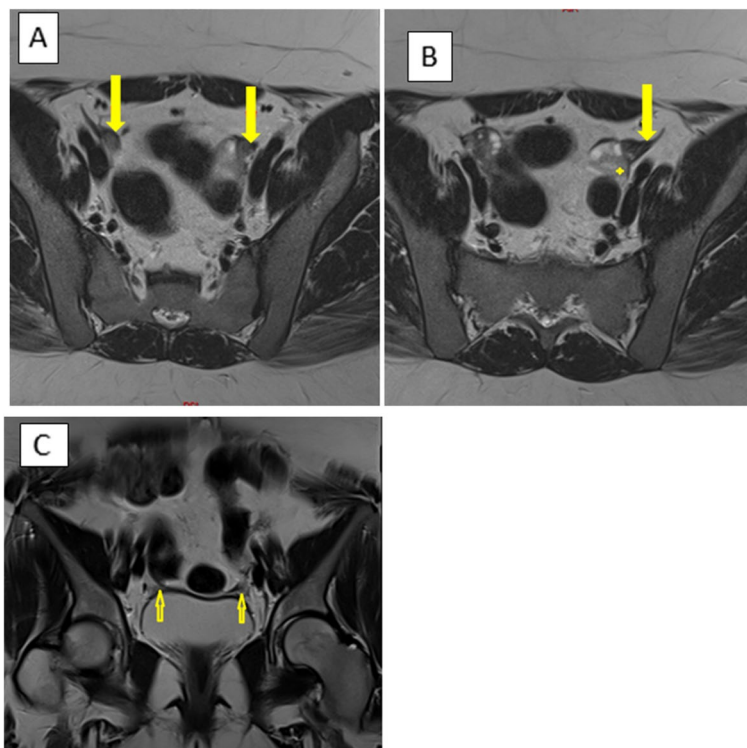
A, B Coronal T2WIs pelvic MRI showed the course of lateral uterine bud (yellow arrow) extends from the lateral side of ovary (yellow star) (A), downward just superior to the level of bladder dome (B) Note the ectopic high location of ovary (yellow star)
